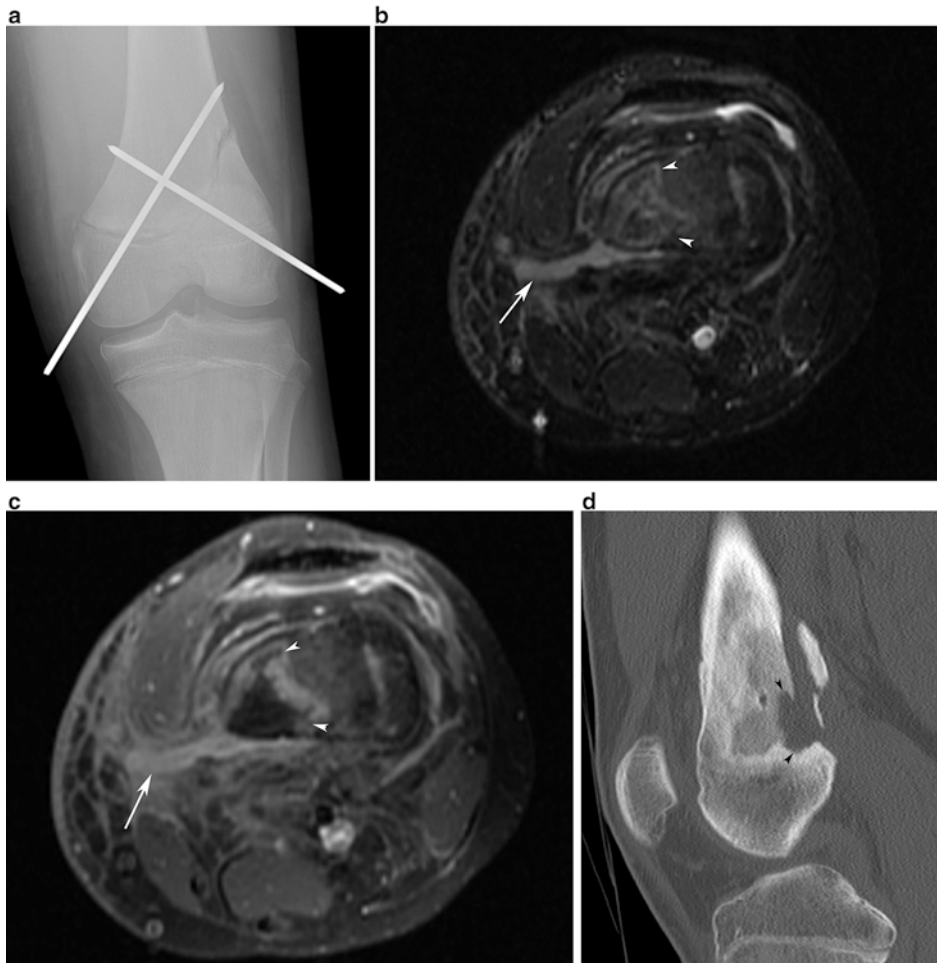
(a) AP radiograph of the knee in a 15-year-old male s/p Salter 2 fracture demonstrates two K wires spanning the fracture through the distal femur and physis. (b) Axial T2-weighted fat-suppressed image through the knee in the same 15-year-old patient 3 weeks after surgery. The pins were removed because they became exposed. MRI reveals an area of signal abnormality within the distal femur (*white arrowheads*) and a bright tract extending from the bone to the subcutaneous soft tissues (*white arrow*), representing an area of infection. (c) Axial T1-weighted, post-contrast, fat-suppressed image through
